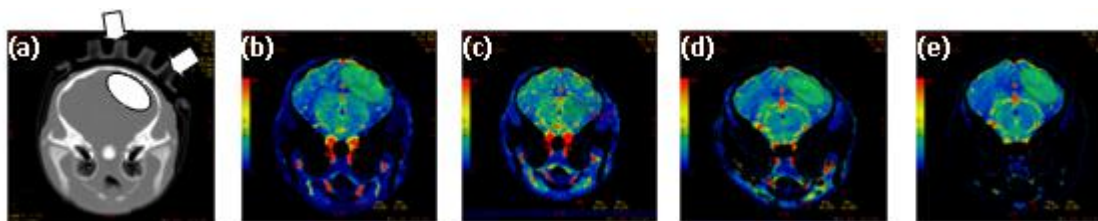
(a) Coronal CT image showing the location of the TR-NIR probes and the ROIs enclosing a ellipse-shaped trajectory that light travel from the source to the detector. (b-e) Corresponding CBF maps at 38° (normothermia), 36°, 34° and 32°C. The region of interest used to measure CBF from the CBF map in each case is also shown.
